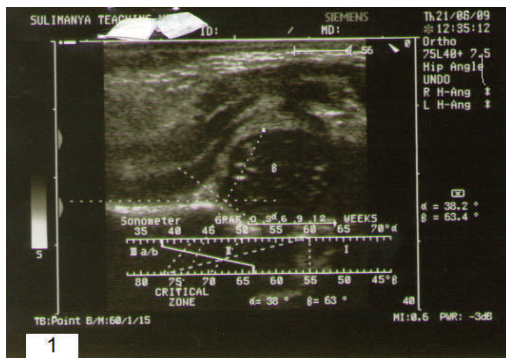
ultrasound of the left hip joint shows decentered hip Graf III (1), however treated with traction, adductor tenotomy and subsequent Pavlik harness becomes centred(Graf IIc), still need treatment
